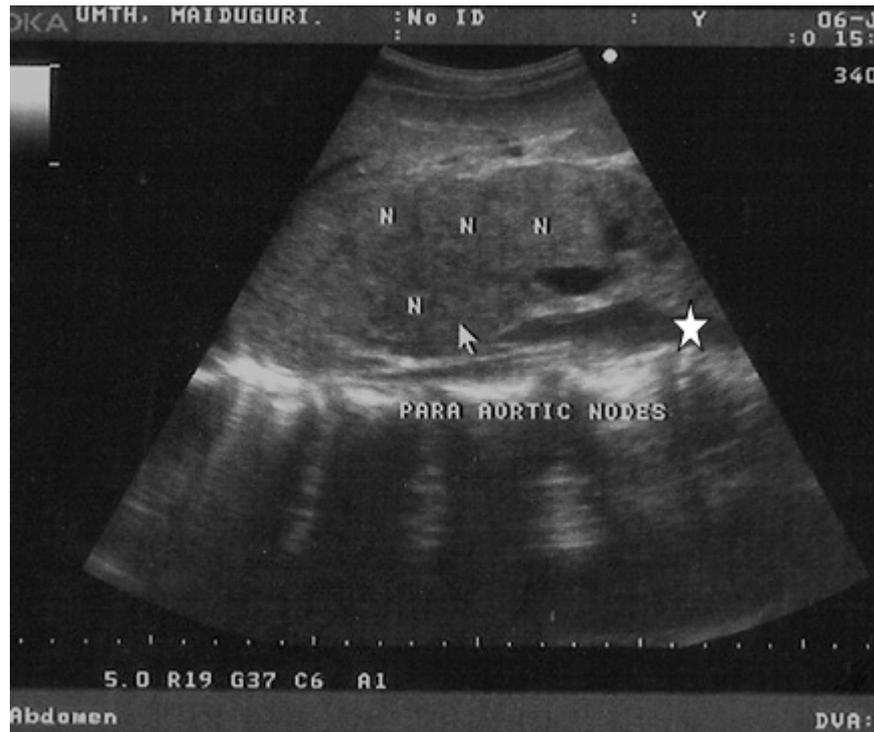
Abdominal ultrasonography (longitudinal view) showing multiple matted para-aortic lymph nodes (N). Aorta was depicted by the white star.
